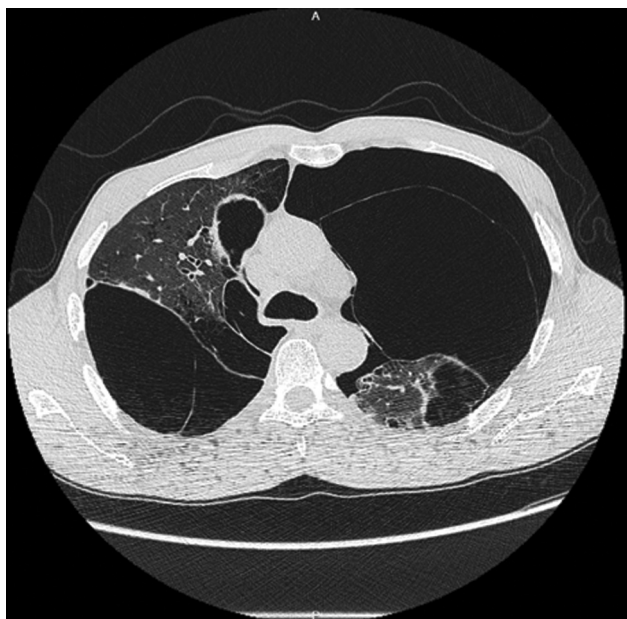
CT image of secondary spontaneous pneumothorax in a young patient with severe bullous disease secondary to cannabis and tobacco use. CT, computed tomography.
